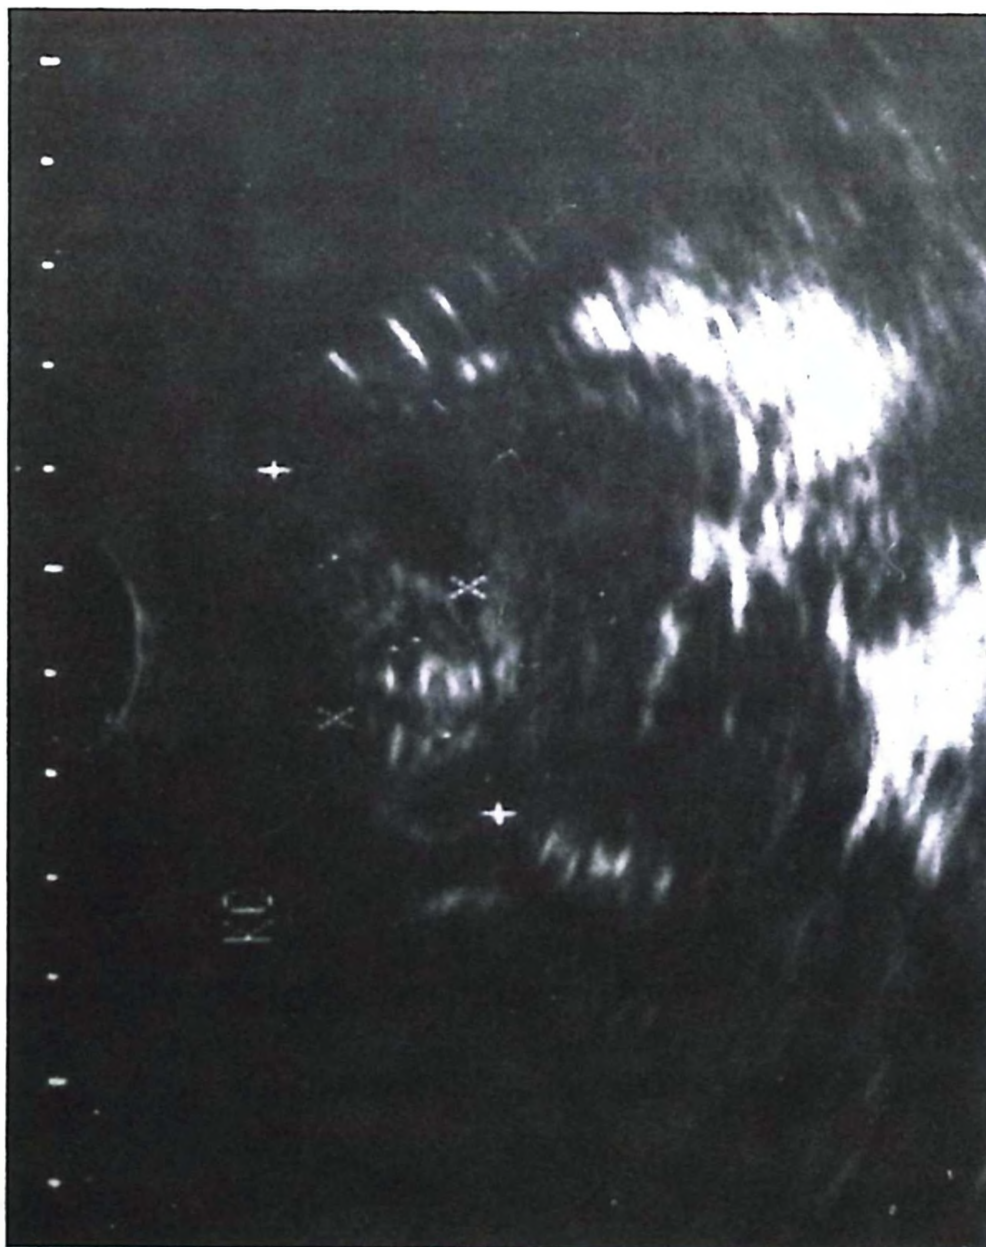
Ultrasonography of the liver shows hyperechogenic ascaris worm within the intrahepatic bile duct.
